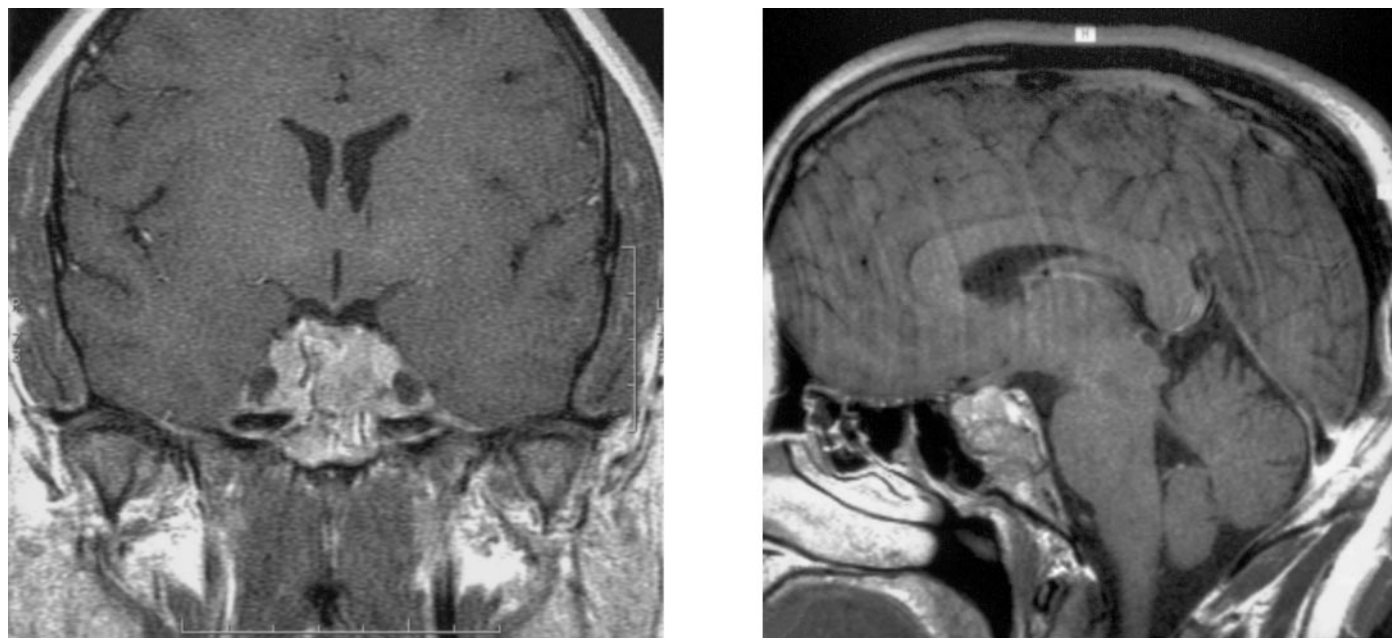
MRI of the pituitary gland in coronal (A) and sagittal (B) views before initiation of dopamine agonist therapy. The adenoma extends into both cavernous sinuses and encases both internal carotid arteries. The mass is in contact with but does not compress the optic chiasm. Repeated imaging after the introduction of dopamine agonist therapy on a yearly basis has revealed mild (~10%) reduction in tumor size.
